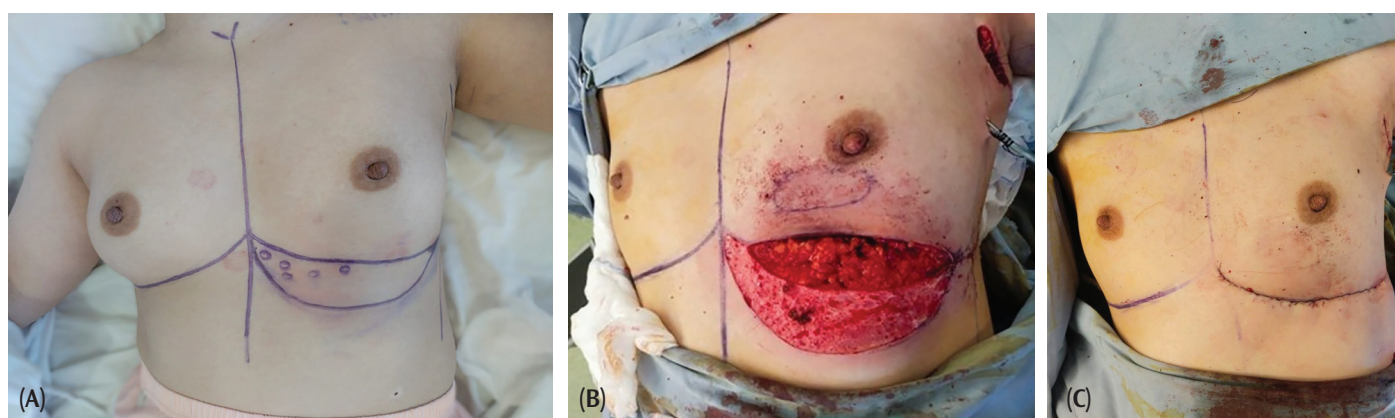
Use of the MICAP flap for volume replacement following resection of lower inner quadrant tumour. (A) Pre-operative marking outlining MICAP flap design with perforators identified and marked using hand-held Doppler, (B) Intra-operative view demonstrating the preparation of the MICAP flap, and (C) Immediate post-operative outcome showing satisfactory contour restoration
